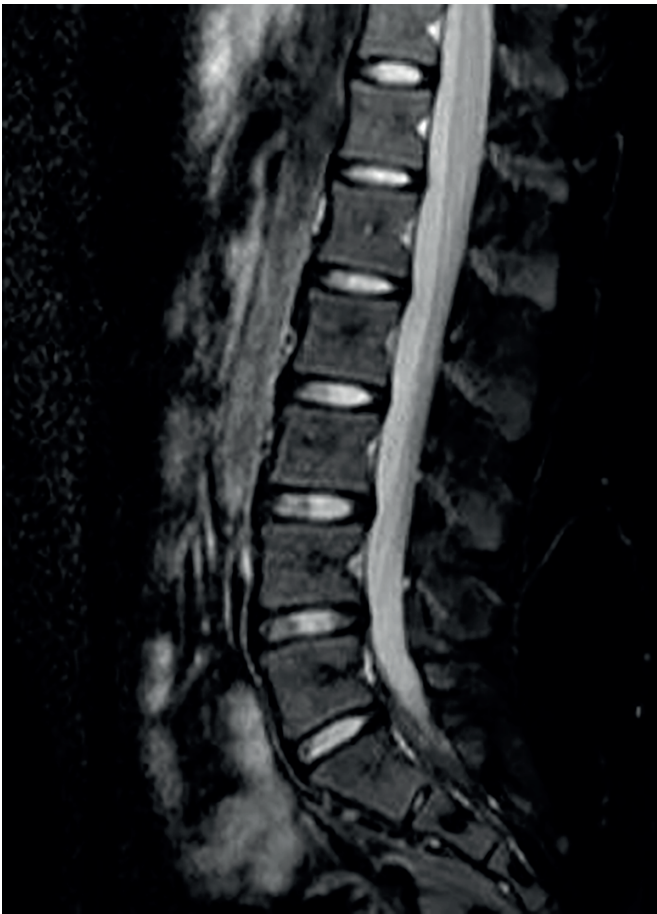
(A) Lumbosacral spine MRI without contrast. (B) Resonance showing sign alteration in the medullary cone with contrast enhancement, as well as in some roots of the cauda equina.
